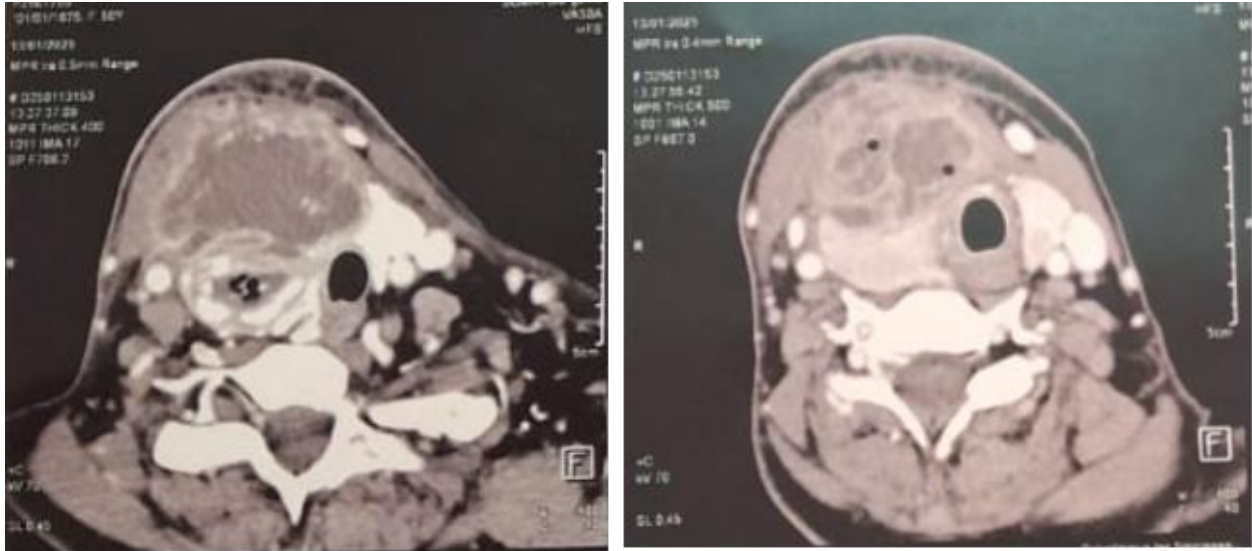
Cervical CT Scan :heterogeneous thyroid lesion measuring 8 cm.
